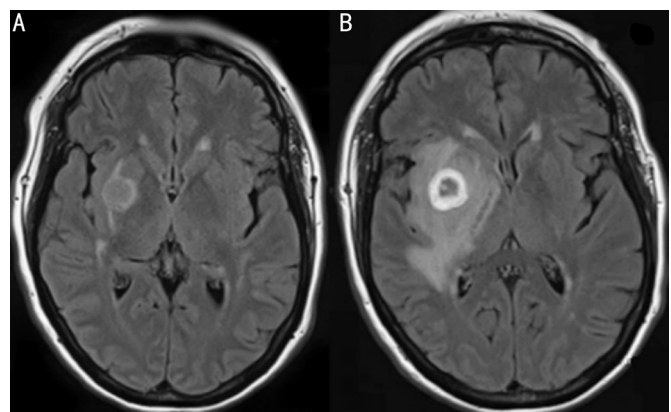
Axial MRI brain imaging A: Circumscribed lesion of the right temporal lobe; B: Ring enhancing lesion with marked surrounding vasogenic oedema at 4mo follow-up.
